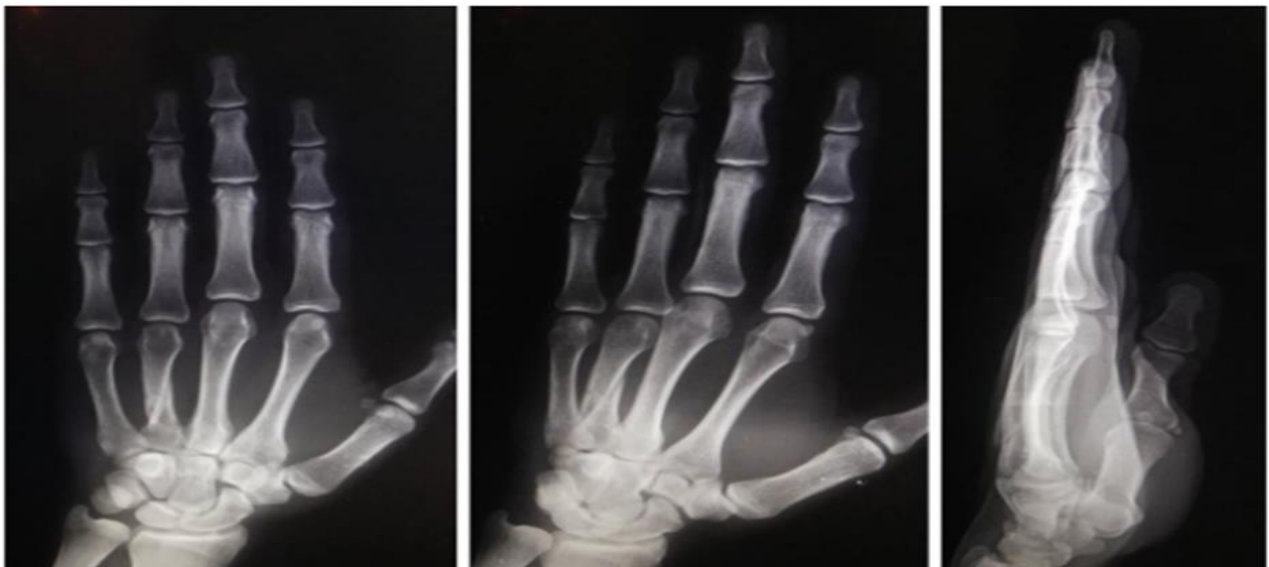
Plain x-ray at the 8th week post-operative after removal of k-wires shows a stable united fracture.
